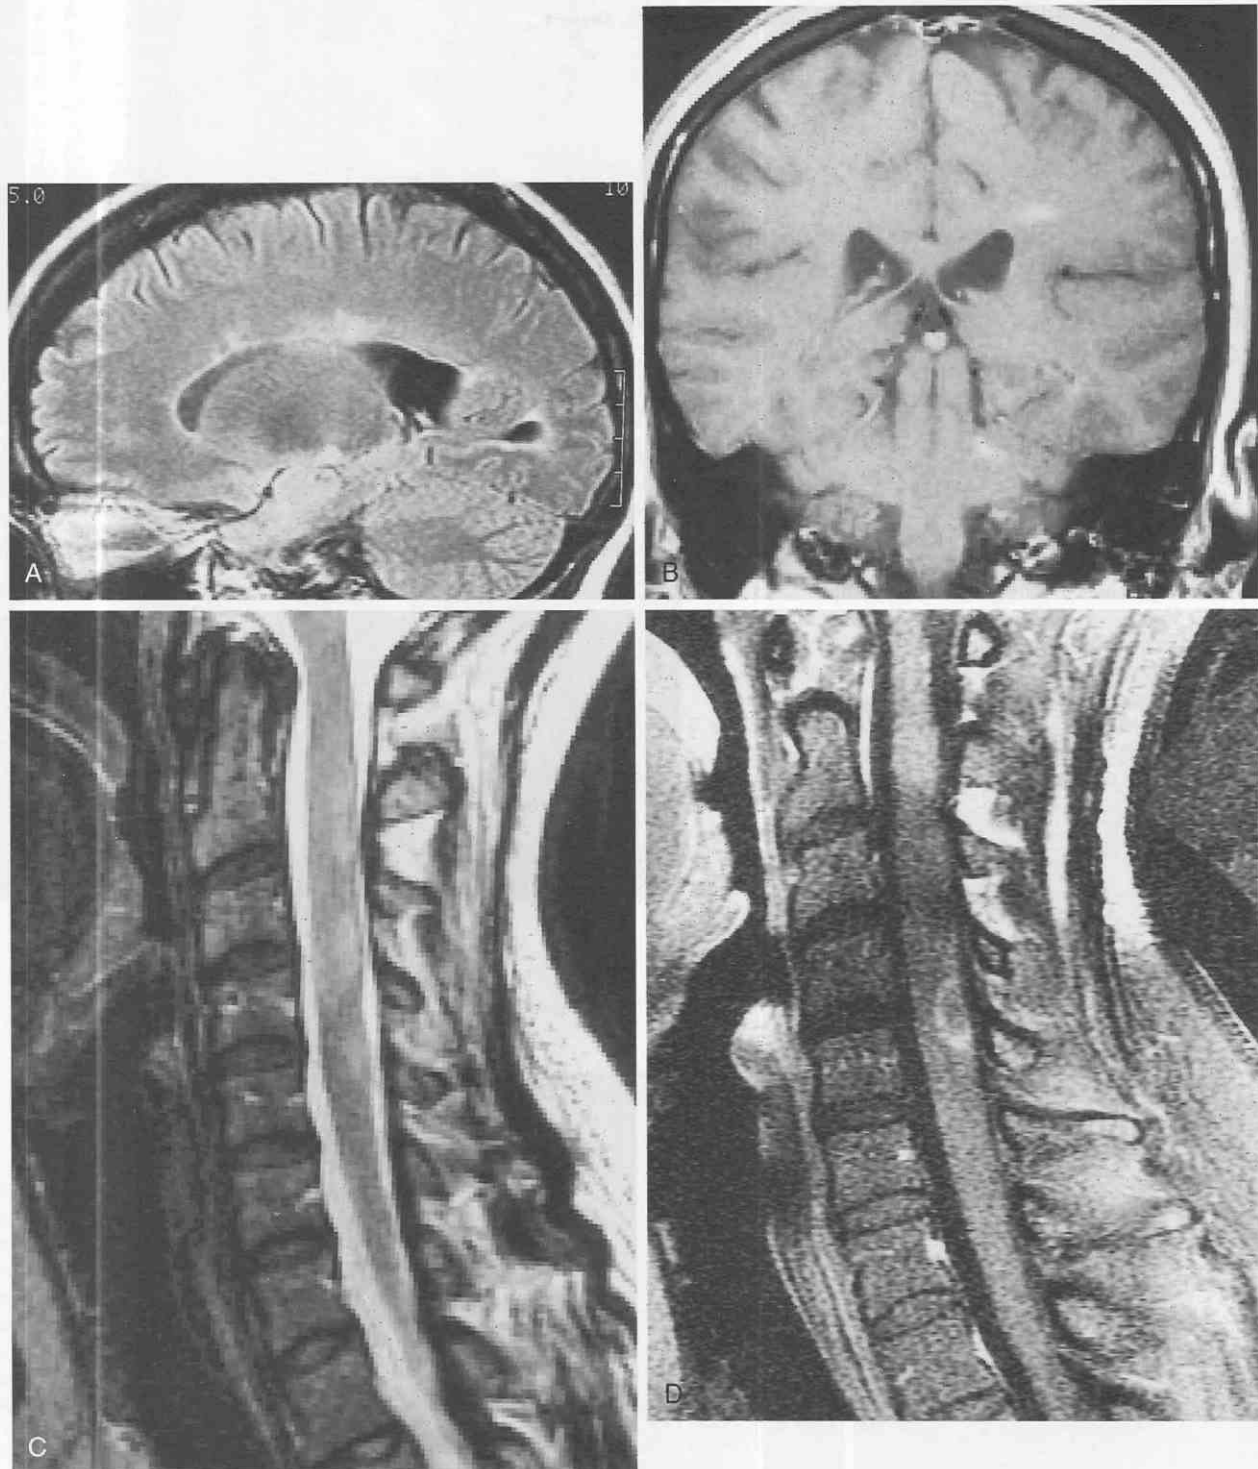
MRI features in a 32-year-old woman with spinal and cerebral multiple sclerosis (MS). *A*, Parasagittal fluid-attenuated inversion recovery (FLAIR) sequence. Numerous hyperintense plaques are clustered on the inferior surface of the corpus callosum, highly correlated with the diagnosis of MS. *B*, Contrast-enhanced, T1-weighted, magnetization-transfer coronal image; two enhancing plaques are visible, indicating active demyelination: one in the corona radiata, the other in the brachium pontis. *C*, Sagittal T2-weighted, fast spin-echo MRI of the cervical spinal cord. Numerous plaques are visible, some with evident swelling (edema). *D*, Fat-suppressed, contrast-enhanced image at the same level as in *C*; one of the lesions has ringlike enhancement.
